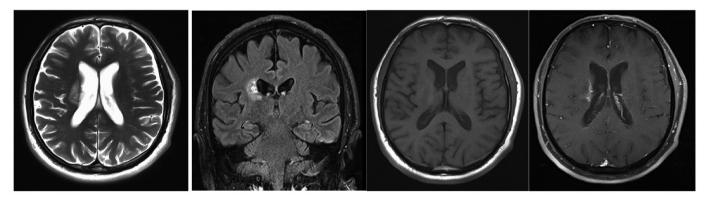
Magnetic resonance images of the patient after three weeks of treatment. Left to right: T2 axial, flair coronal, T1 axial precontrast, T1 axial post-contrast
